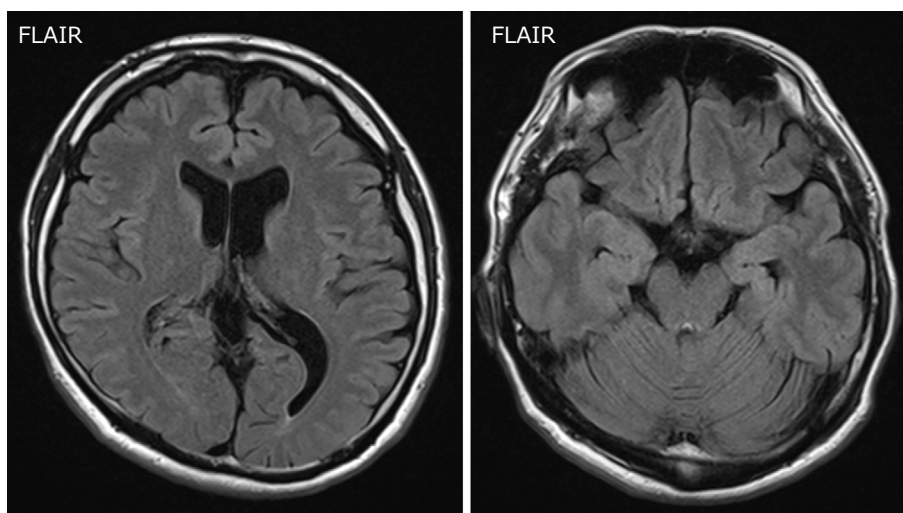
MRI showing atrophy of the left hippocampus and age-inappropriate cerebral atrophy. T2-FLAIR: T2-weighted fluid-attenuated inversion recovery
